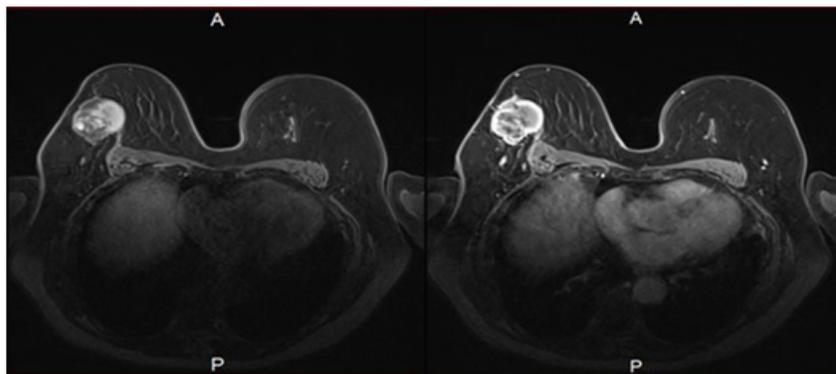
Breast magnetic resonance imaging (MRI), contrast-enhanced T1-weighted image showed ball-like tumor, rim enhancement, and segmental internal enhancement. The time intensity curve following administration of gadolinium showed rapid-plateau manifestation appearing like a benign tumor.
